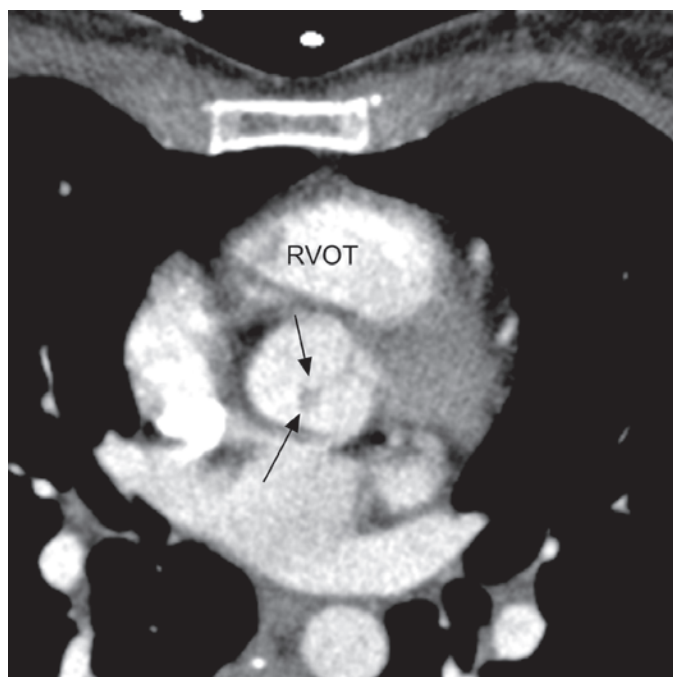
Axial image of an electron beam CT data set at the level of the aortic valve. A small papillary fibroelastoma can be depicted at the tip of the aortic valve cusps (arrows). RVOT, right-ventricular outflow tract.
